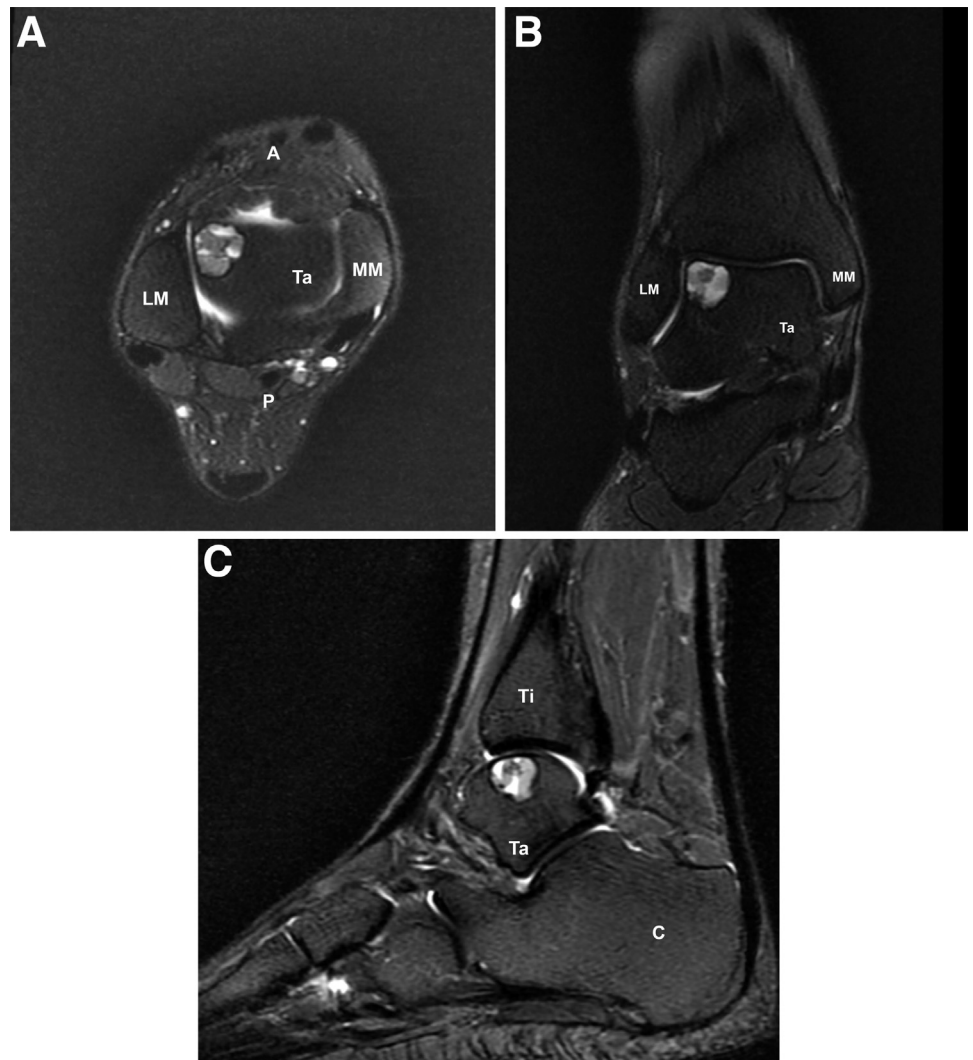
(A-C) Axial, coronal, and sagittal computed tomography images of the talar subchondral cyst (A, anterior; C, calcaneus; F: Fibula; LM, lateral malleol; MM, medial malleol; P, posterior; Ta, Talus; Ti, Tibia.)
